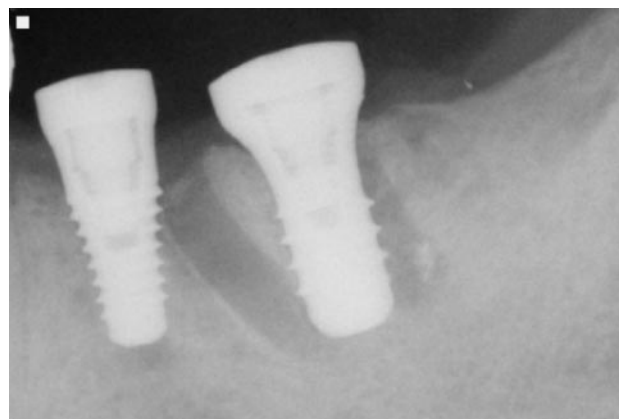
A radiograph taken after 42 months in function demonstrates the stability of the crestal peri-implant bone around both implants.
